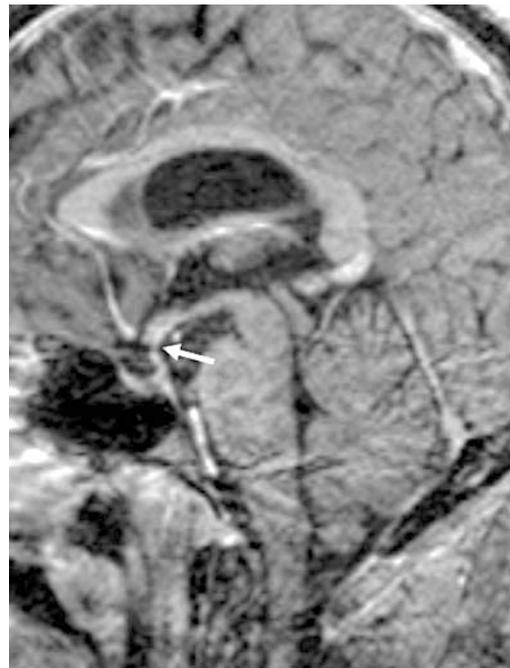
After 3 months of steroid therapy, a sagittal contrast-enhancement T1-weighted image demonstrates a significant reduction of the hypothalamic and infundibular lesion (*arrow*)
